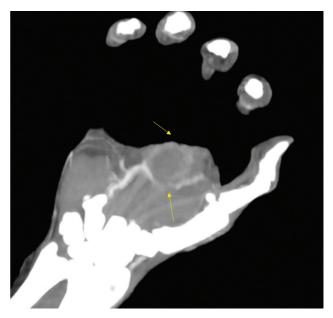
Computed tomography angiography image in axial projection: thrombosed traumatic pseudoaneurysm.
